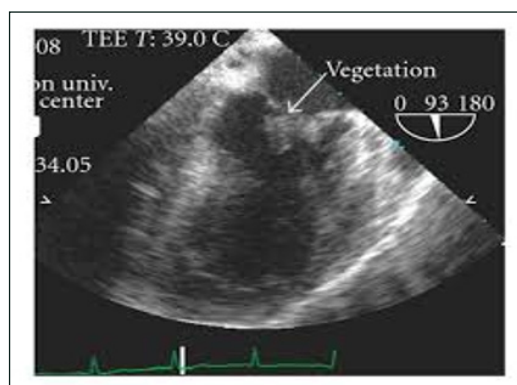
and Figure 3: Transesophageal Echocardiography (TEE) Revealed Vegetation on Anterior Mitral Valve Leaflet and Doppler TEE showed Mitral Regurgitation
